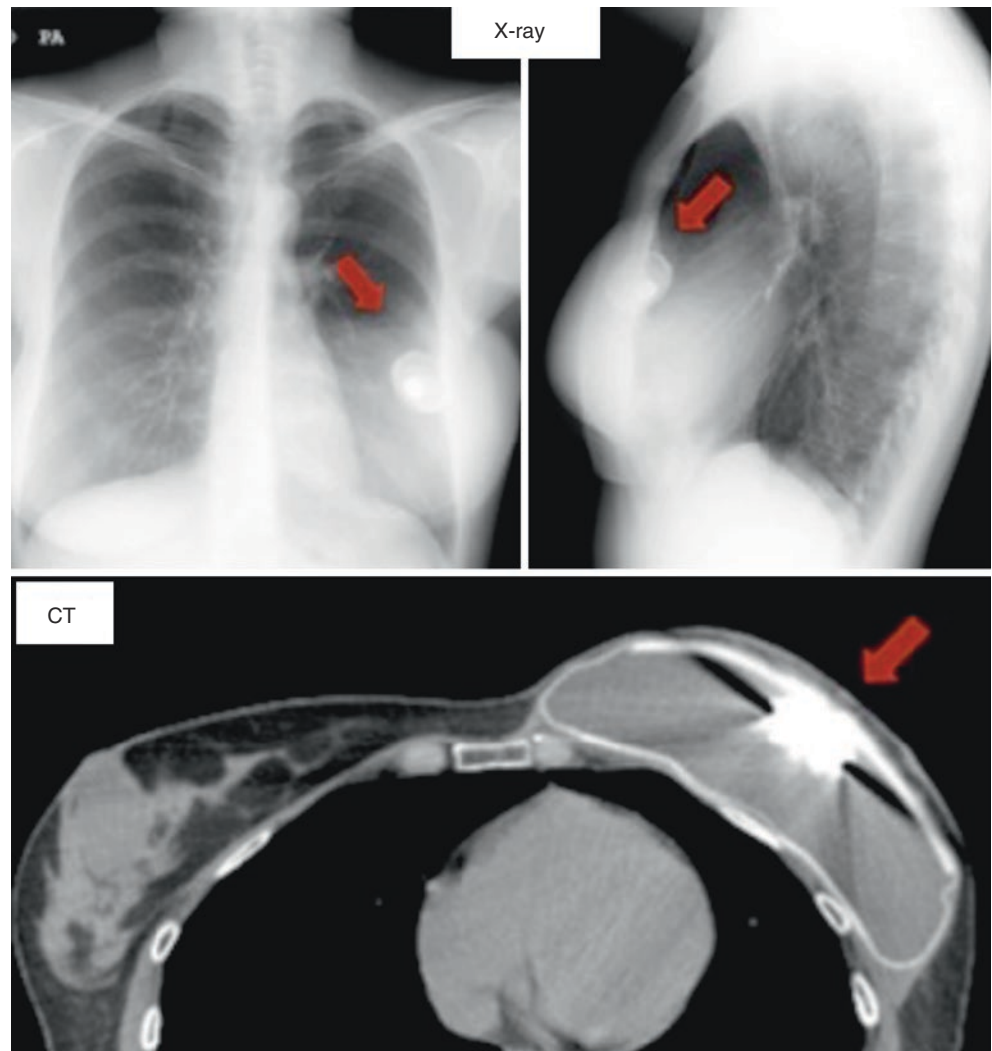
Patient with personal history of right mastectomy and temporary reconstruction with an expander with a metallic valve. Breast MRI was performed due to surgeon request in the case of suspected rupture. There was no contraindication for the MRI except that it was not useful to evaluate either the operated breast or the expander, being
